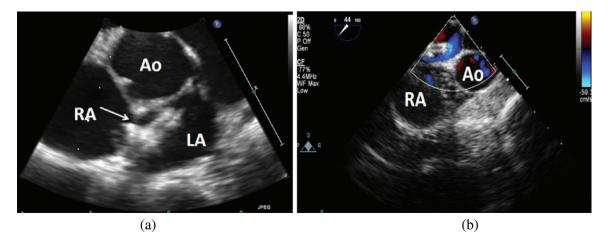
Transesophageal echocardiogram demonstrating malaligned septum with secundum atrial septal defect (arrow) measuring 7 mm (a). Transesophageal echocardiogram showing device closure with 25 mm GORE CARDIOFORM Septal Occluder (arrow) (b). Note device position relative to a ra and absence of shunting by color flow imaging
